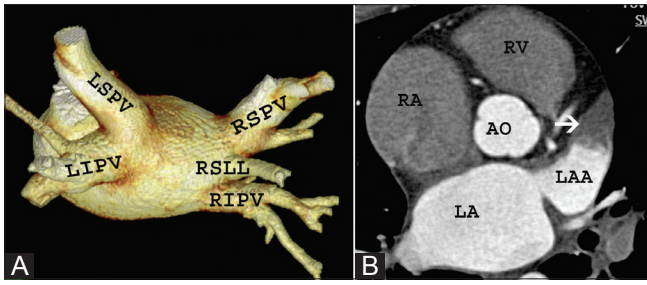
(A, B): Pulmonary vein evaluation. Three-dimensional volume-rendered image (A) shows a common ostium for the left superior pulmonary vein (LSPV) and the left inferior pulmonary vein (LIPV). On the right, in addition to the normal ostia for the right superior pulmonary vein (RSPV) and the right inferior pulmonary vein (RIPV), there is an accessory ostium for the vein draining the superior segment of the right lower lobe (RSLP). Axial CT scan (B) in a patient with atrial fibrillation shows a hypodense lesion in the left atrial appendage (arrow), consistent with a thrombus. LA – left atrium, RA – right atrium, LAA – left atrial appendage, RV – right ventricle, AO – aorta
